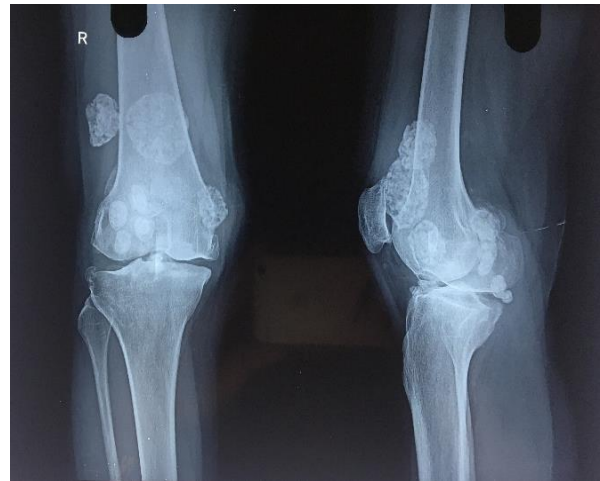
Antero-posterior, lateral x-ray of right knee showing multiple loose bodies.
